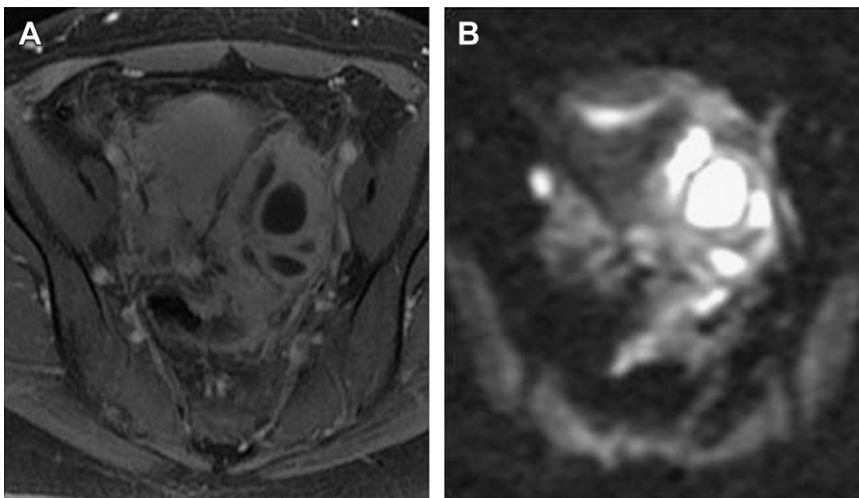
TOA. Mass with heterogeneous enhancement and high SI on DWI. (A) Axial postcontrast image. (B) DWI.
